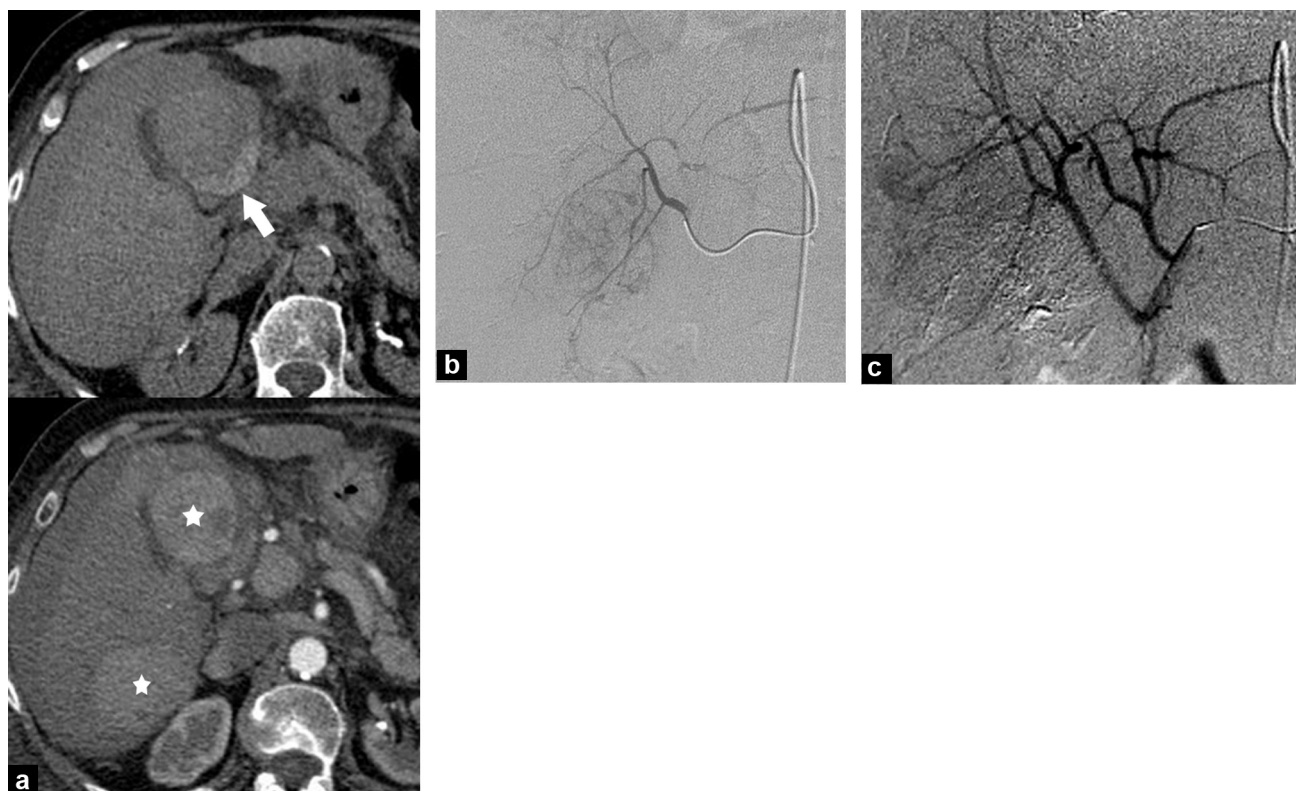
Sudden-onset severe abdominal pain in a patient with clinical signs of cirrhosis: a: abdominal CT with and without enhancement in the arterial phase. Dysmorphic liver with 2 hyperarterialized tumors (stars) and a hemoperitoneum. The sentinel hematoma (arrow) in contact with the lesion in segment IV indicates the hepatocellular carcinoma responsible for the bleed; b: pre-embolization arteriography. Selective catheterization of the branch supplying segment IV confirms the presence of tumor enhancement; c: post-embolization arteriography. In the absence of hemorrhagic shock, Lipiodol tumor embolization could be administered in this emergency situation.
